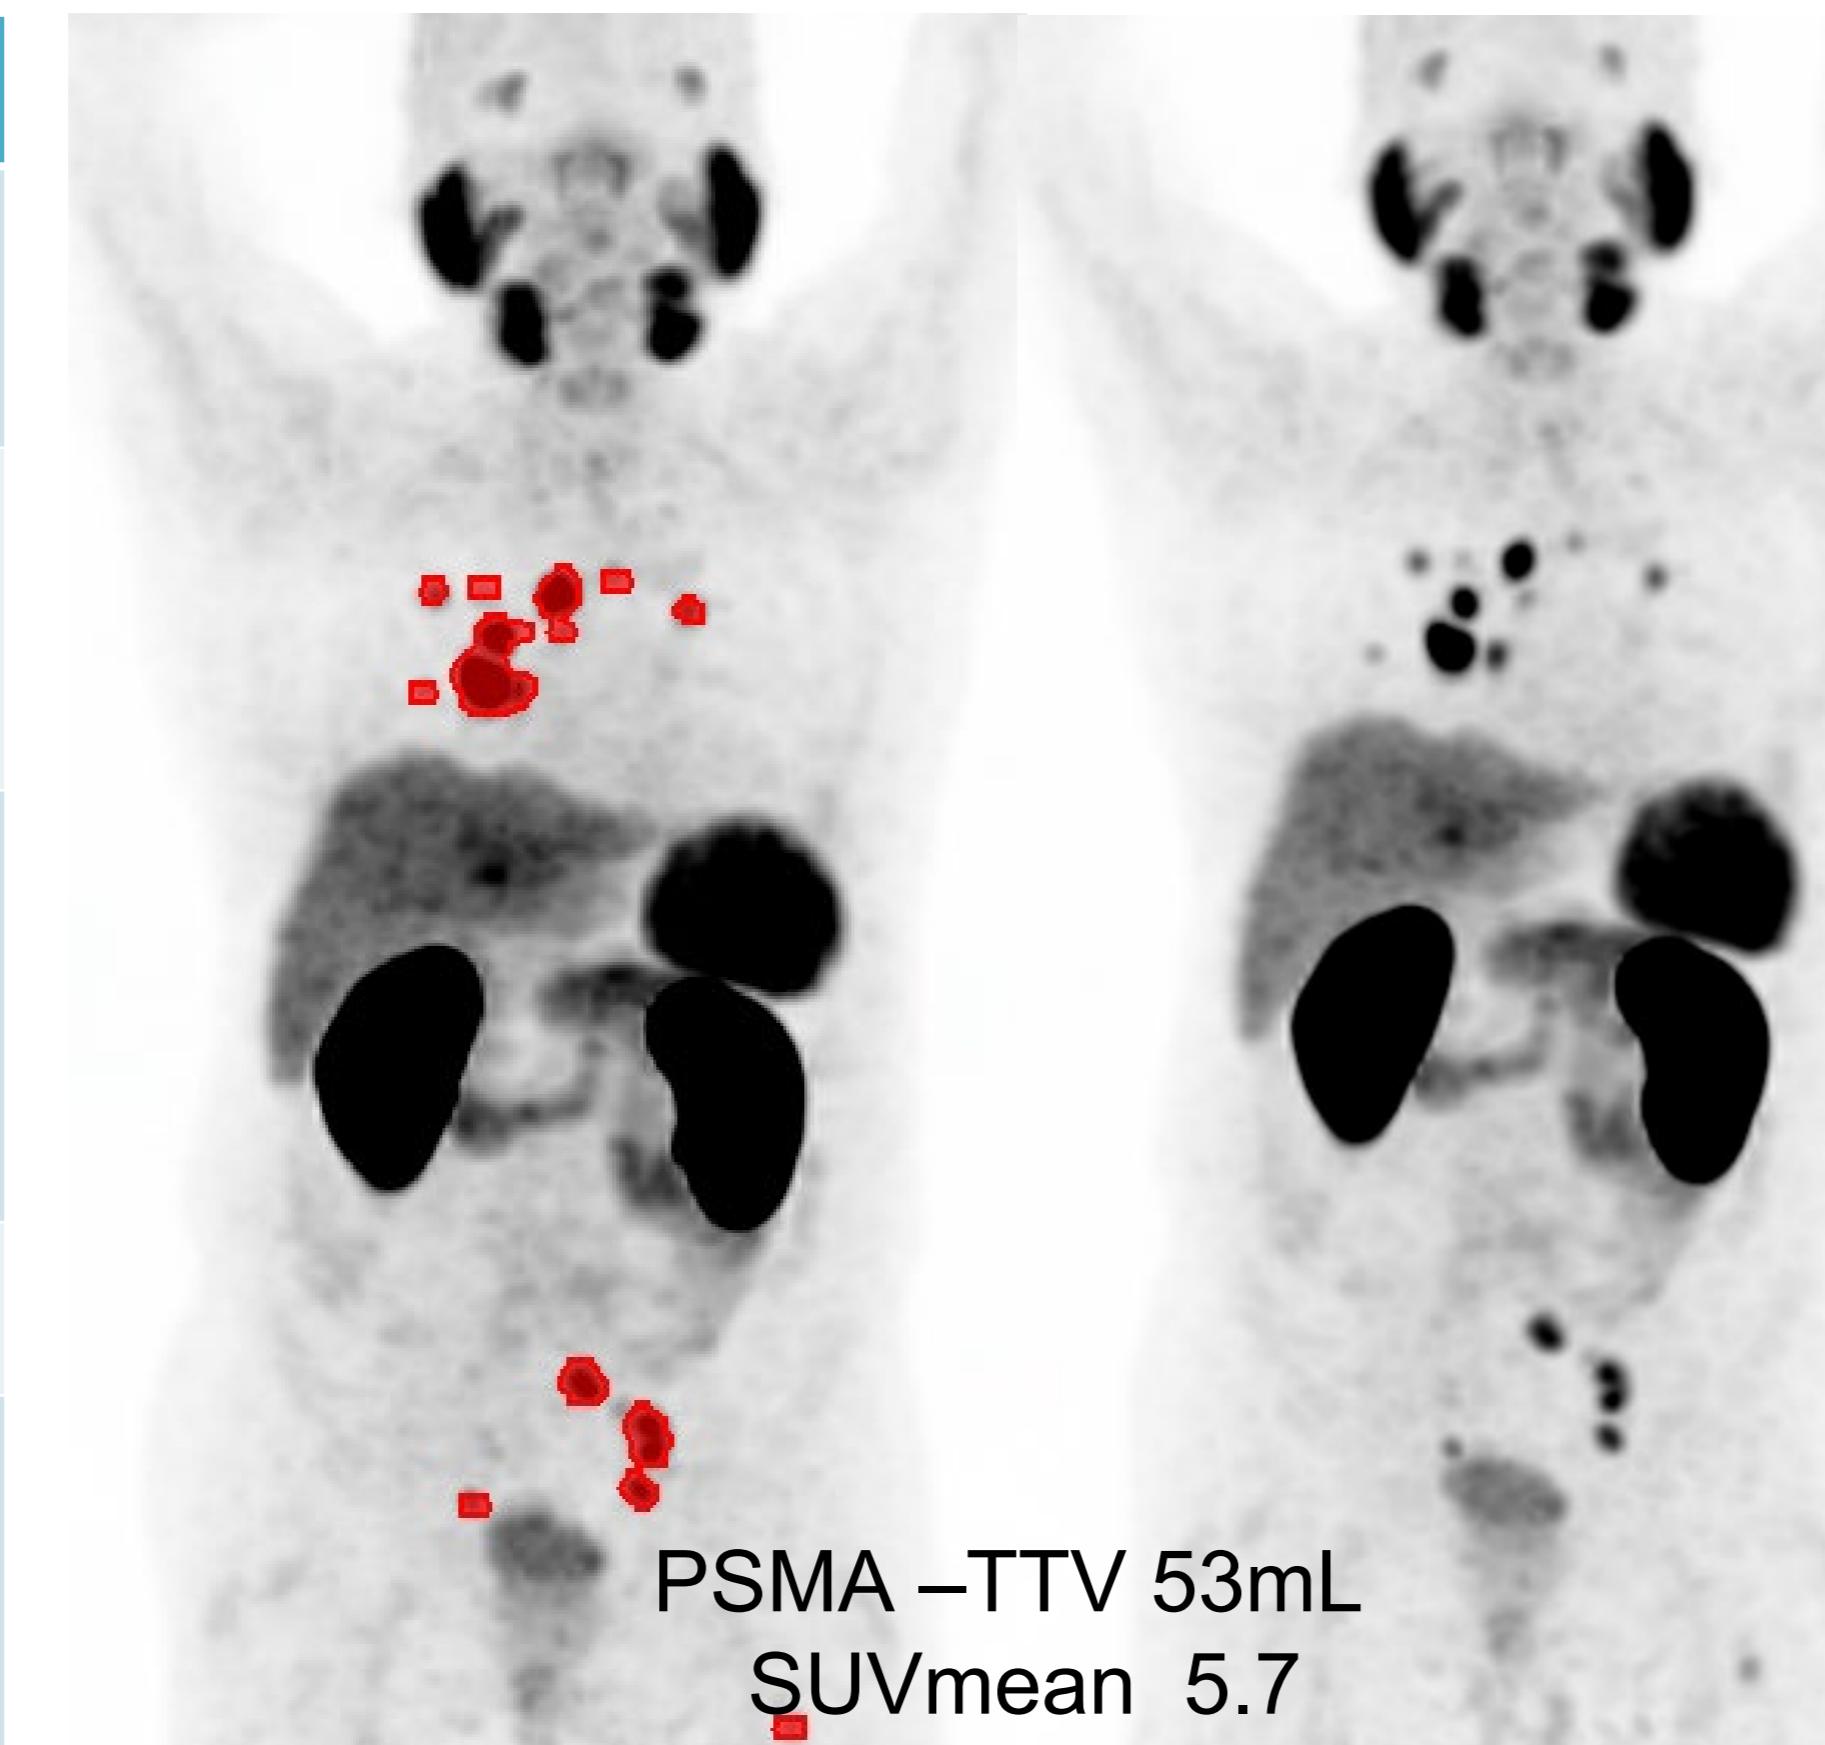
PSMA PET scan with low volume nodal and bone metastases.
